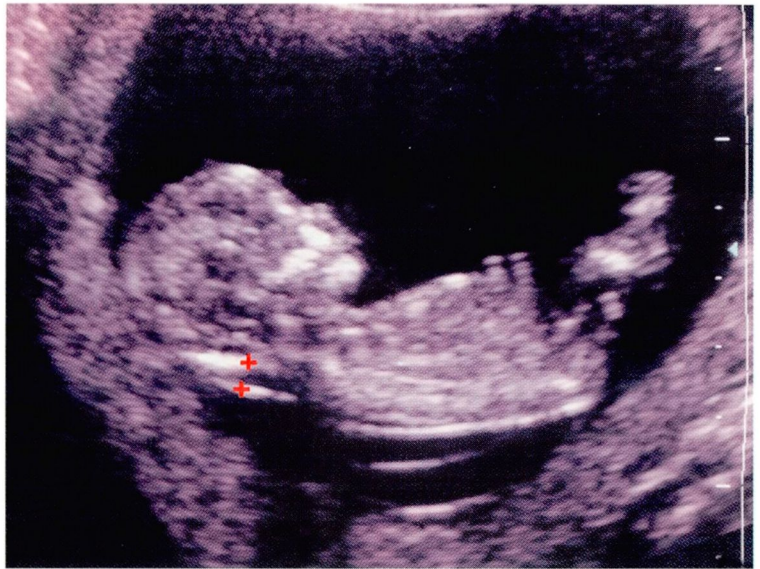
Transvaginal ultrasonogram performed at approximately 10 weeks of gestation because of advanced maternal age. The nuchal thickness or translucency (indicated by the cross-hairs) measured 0.4 cm (upper limit of normal 0.2 cm). Because this finding has been associated with an increased risk of trisomy 21 (Down's syndrome), a transvaginal chorionic villus sampling was performed, indicating that this fetus did have the 47, XY+21 karyotype ie, Down's syndrome.
